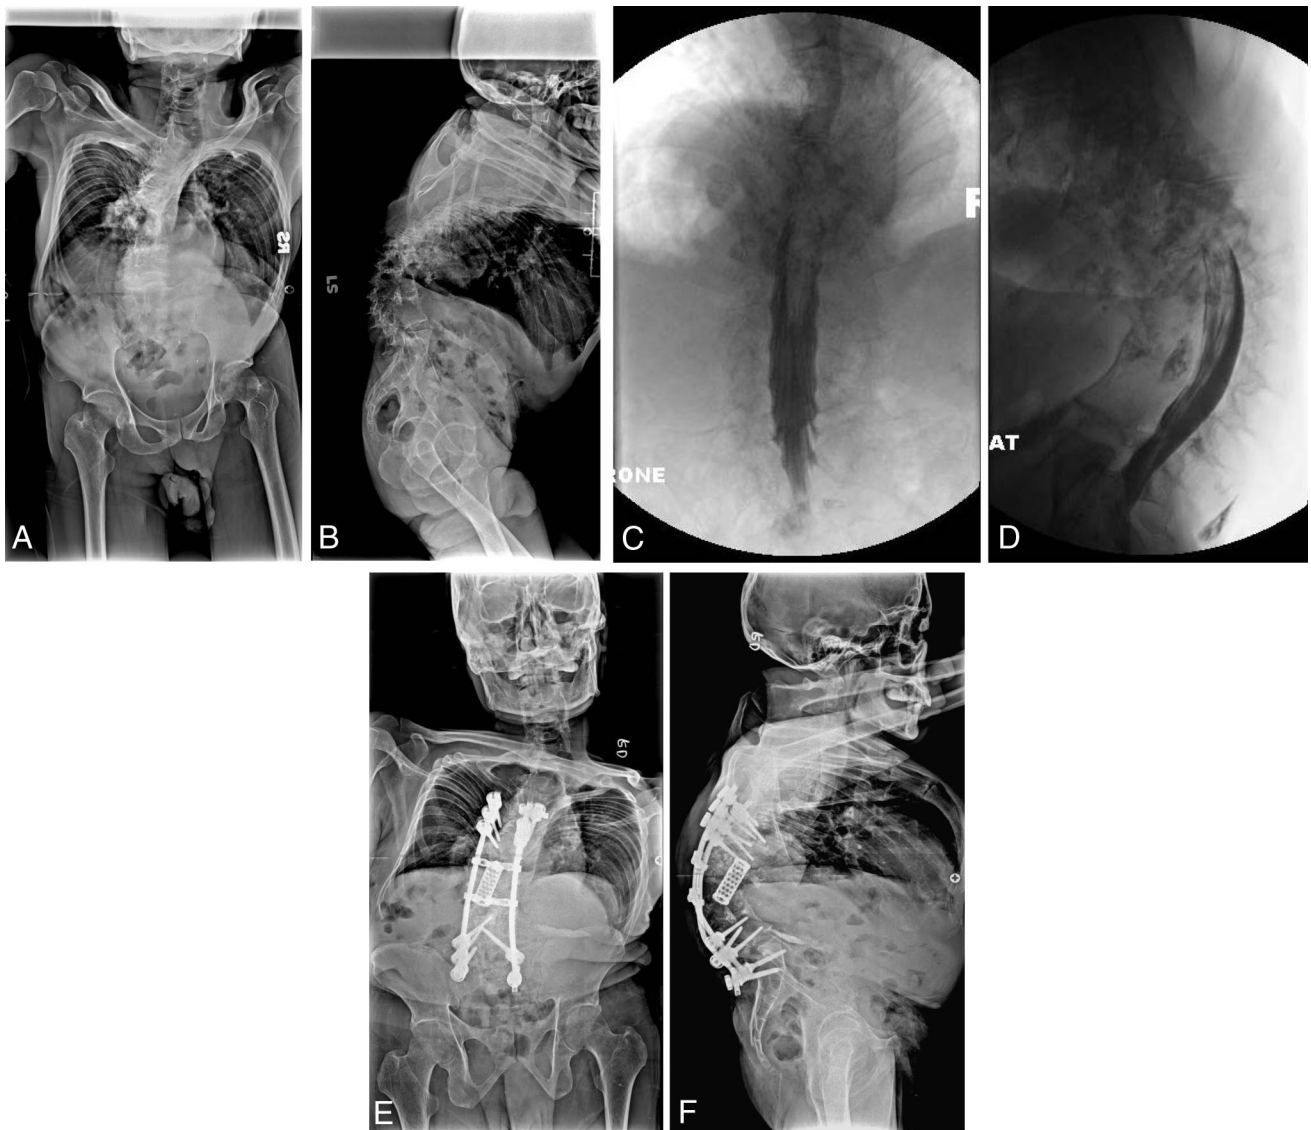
A 52-year-old man with Frankel B neurologic deficits due to postinfectious angular kyphosis. A, B, Preoperative lateral radiograph showed 107° angular kyphosis. C, D, Preoperative myelography revealed cord compromised at the apex. E, F, Postoperative radiographs taken 3.1 year after surgery revealed deformity correction to 68°. Neurologic deficits improved to Frankel E.
